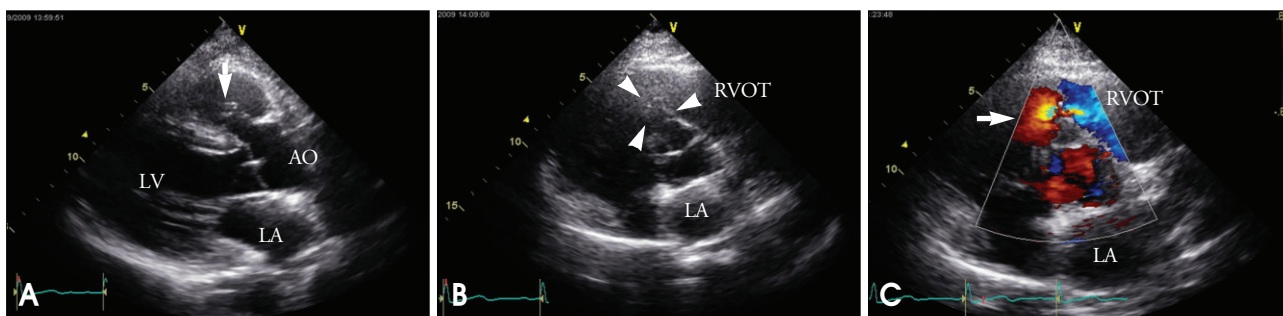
Transthoracic echocardiography. Parasternal long axis view (A) shows an aneurysm of the right sinus of Valsalva (arrow). Parasternal short axis views (B and C) show also the aneurysm (arrowheads) and systolic flow acceleration suggesting the RVOT obstruction (arrow). RVOT: right ventricular outflow tract, LV: left ventricle, LA: left atrium, Ao: aorta.
